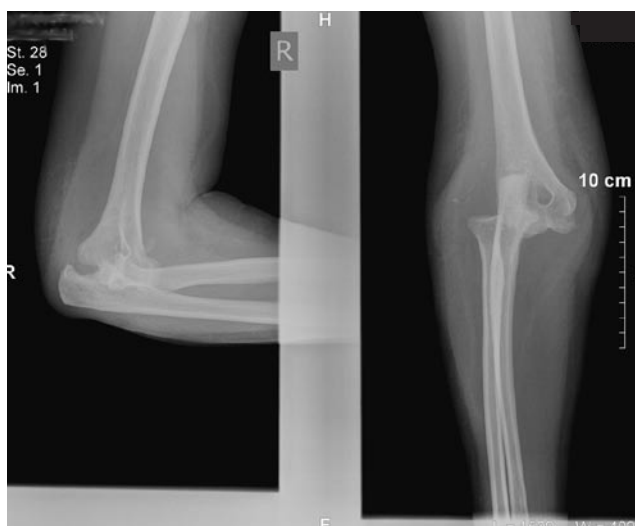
Presenting lateral and anteroposterior radiographs of elbow show chronic posterolateral elbow dislocation with small avulsion fracture.
